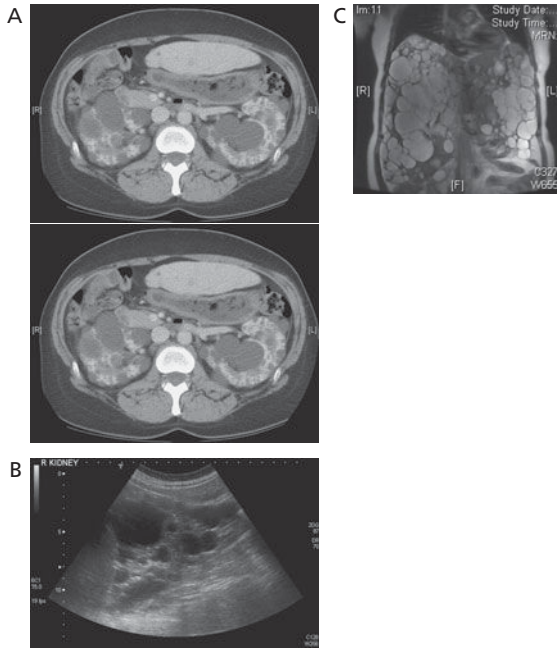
Ultrasound, CT and MR imaging in ADPKD. (A) CT imaging of the abdomen can be used to accurately define the architecture of PKD and PLD and estimate renal volumes. (B) Routine trans-abdominal ultrasound is commonly used to screen for ADPKD in at risk individuals. (C) MR is also of value in imaging PKD and PLD especially when repeated images are required such as in the assessment of massive PLD or serial measurements of renal volume.
